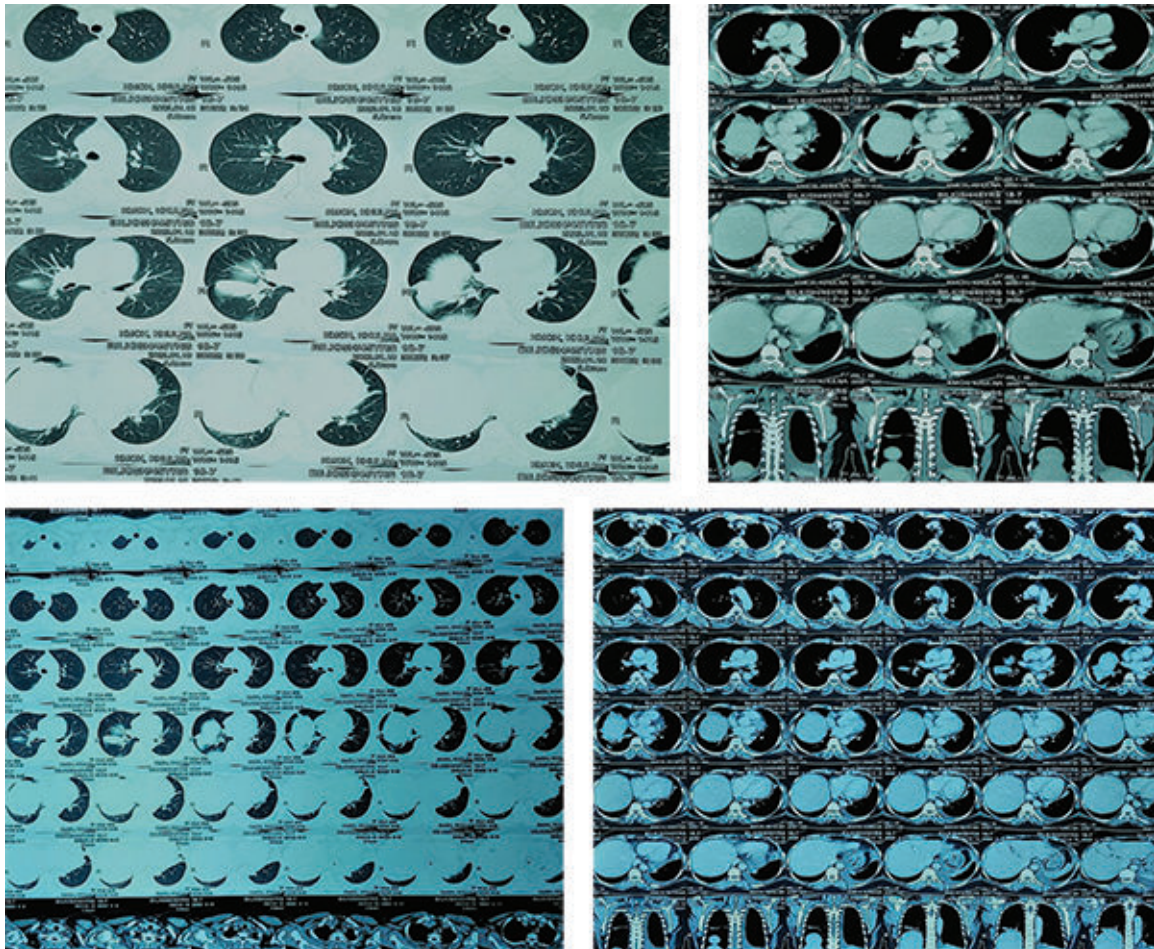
CT scan of the chest showing multiple sections with subtle parenchymal changes, with mild pleural collection/ effusion, suggestive of alveolar haemorrhage.
